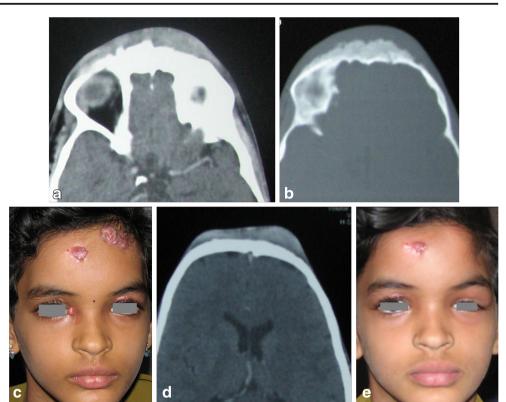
Calvarial (frontal bone) tuberculosis in a 10-year-old girl. a Axial postcontrast CT showing thickening of the frontal bone with erosion of the margins and overlying soft tissue swelling. b Bone window of the same image showing erosion of the outer table of the frontal bone with soft tissue swelling. c Clinical photograph (frontal view) of the patient showing multiple punched out skin lesions on the forehead, inner canthus, and upper eyelid region. d Axial CT image showing healed frontal bone on antituberculous chemotherapy. The overlying soft tissue swelling has also reduced in size. e Clinical photograph (frontal view) of the patient showing the healed skin lesions as previously depicted
